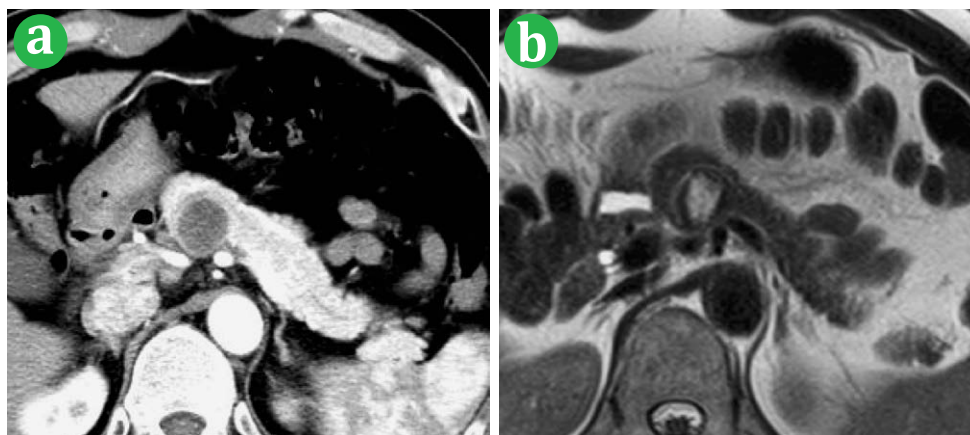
Cystic and hyperenhancing tumor (Non-functional tumor, G2). (a). A Dynamic computed tomography scan image obtained during the arterial phase shows a large mass with solid and cystic components. (b). A T2-weighted magnetic resonance image shows a small lesion with high signal intensity.
